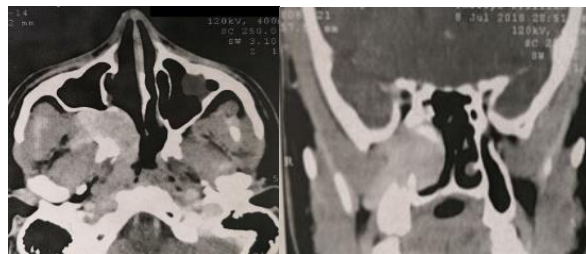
CT image showing angiofibroma shows a mass in right side of the nasal cavity and a grossly enlarged sphenopalatine fissure to reach PPF and extended to ITF. The posterior wall of the right maxillary sinus is bowed anteriorly creating the classic Holman-Miller sign. The right pterygoid is partially destroyed involving pterygopalatine fossa, infra temporal fossa and nasal cavity. (Stage IIIA)
